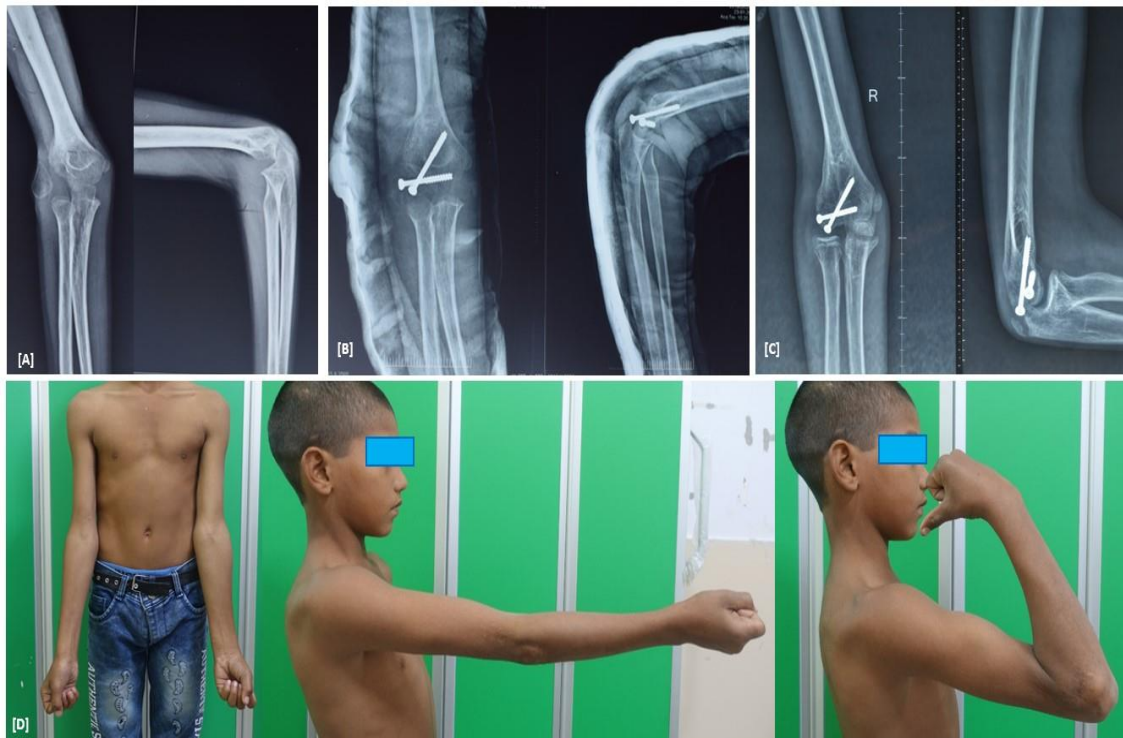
11 years male presented at 8 weeks presented with complaints of decreased elbow motion, managed with in-situ fixation and bone grafting. A: Initial radiograph at presentation showing AP view of X-ray, B: immediate post-op X-ray; C: X-ray at two months follow up; D: X-ray at one year of follow up, E: Clinical image at one year of follow up.
